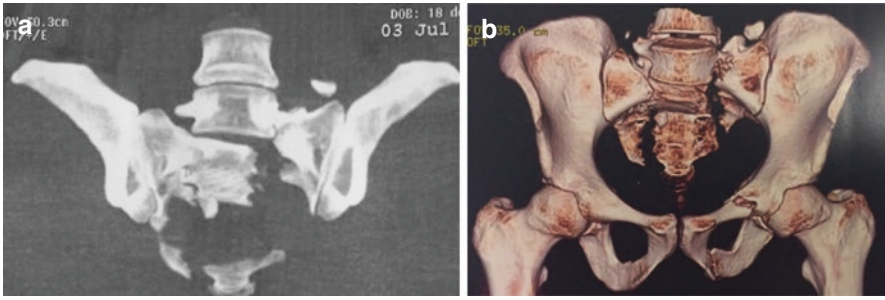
Type C3 injury; (a) CAT scan (b) CT 3D reconstruction
